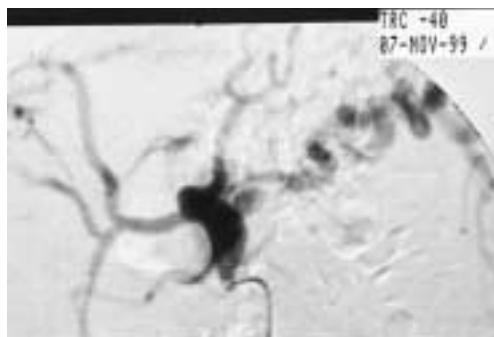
Later film showed clearly that aneurysm was thrombosed in its greater part; the central part filled with blood exhibited colour signal at CDUS (s. Figure 2), peripheral crescent-like blood filling in the caudal part corresponded to anechoic clefts at the periphery (s. Figure 1), and caused no Doppler signal because of slow flow.
